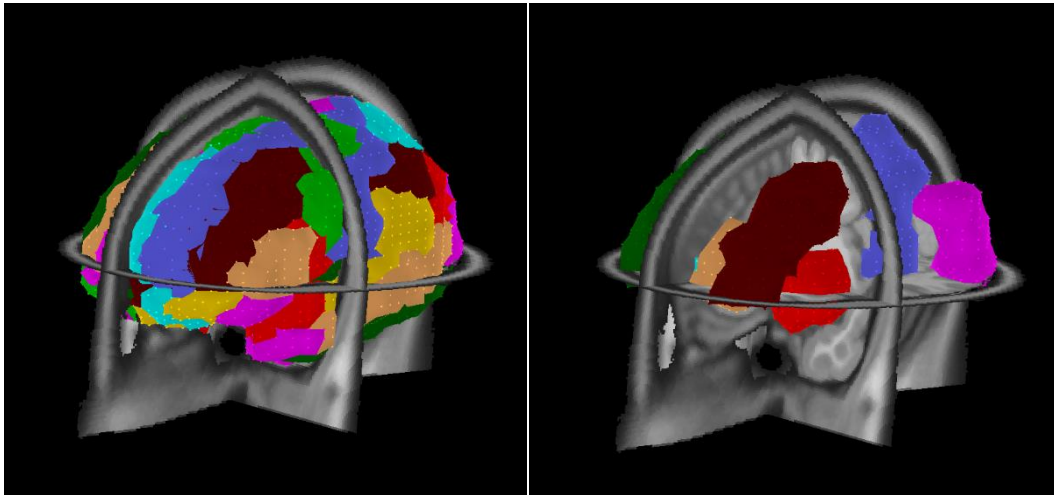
3D MRI view of the complete AAL volume atlas on the left, and on the right the ROIs in this atlas; dlPFC (burgundy), dACC (orange), Insula (red), S1 (blue), V1 (magenta) and thalamus (not visible in this image).
